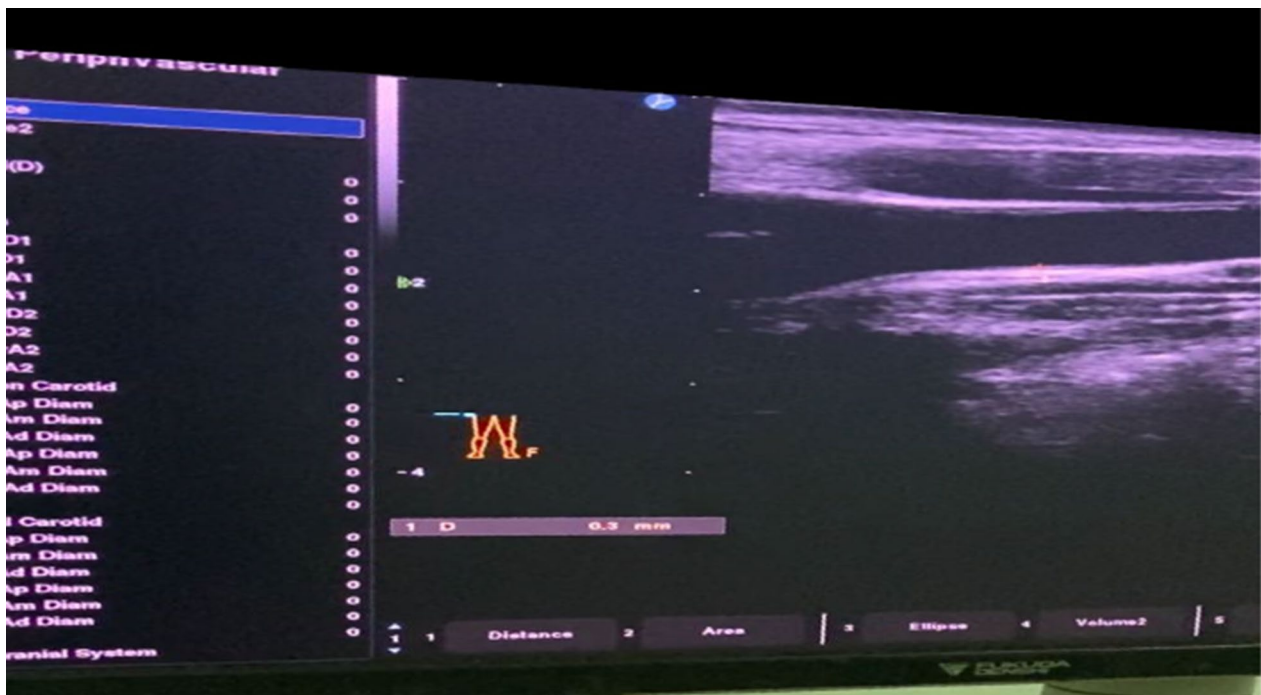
B-mode ultrasound of the common carotid artery shows the IMT with a value=0.3 mm
